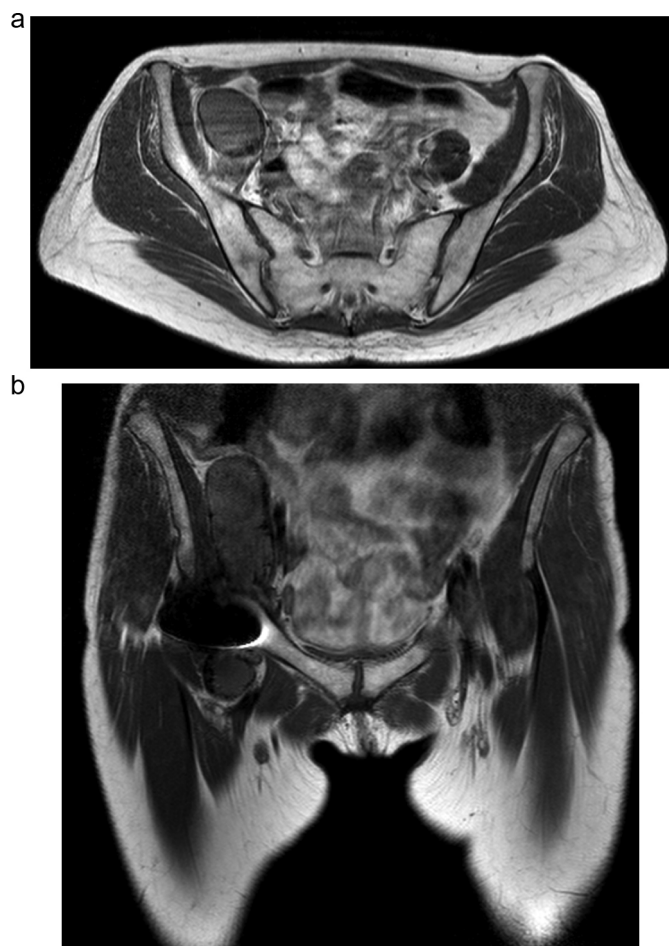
T1 weighted Magnetic Resonance Image (a) axial and (b) coronal demonstrating large intra-pelvic mass.
